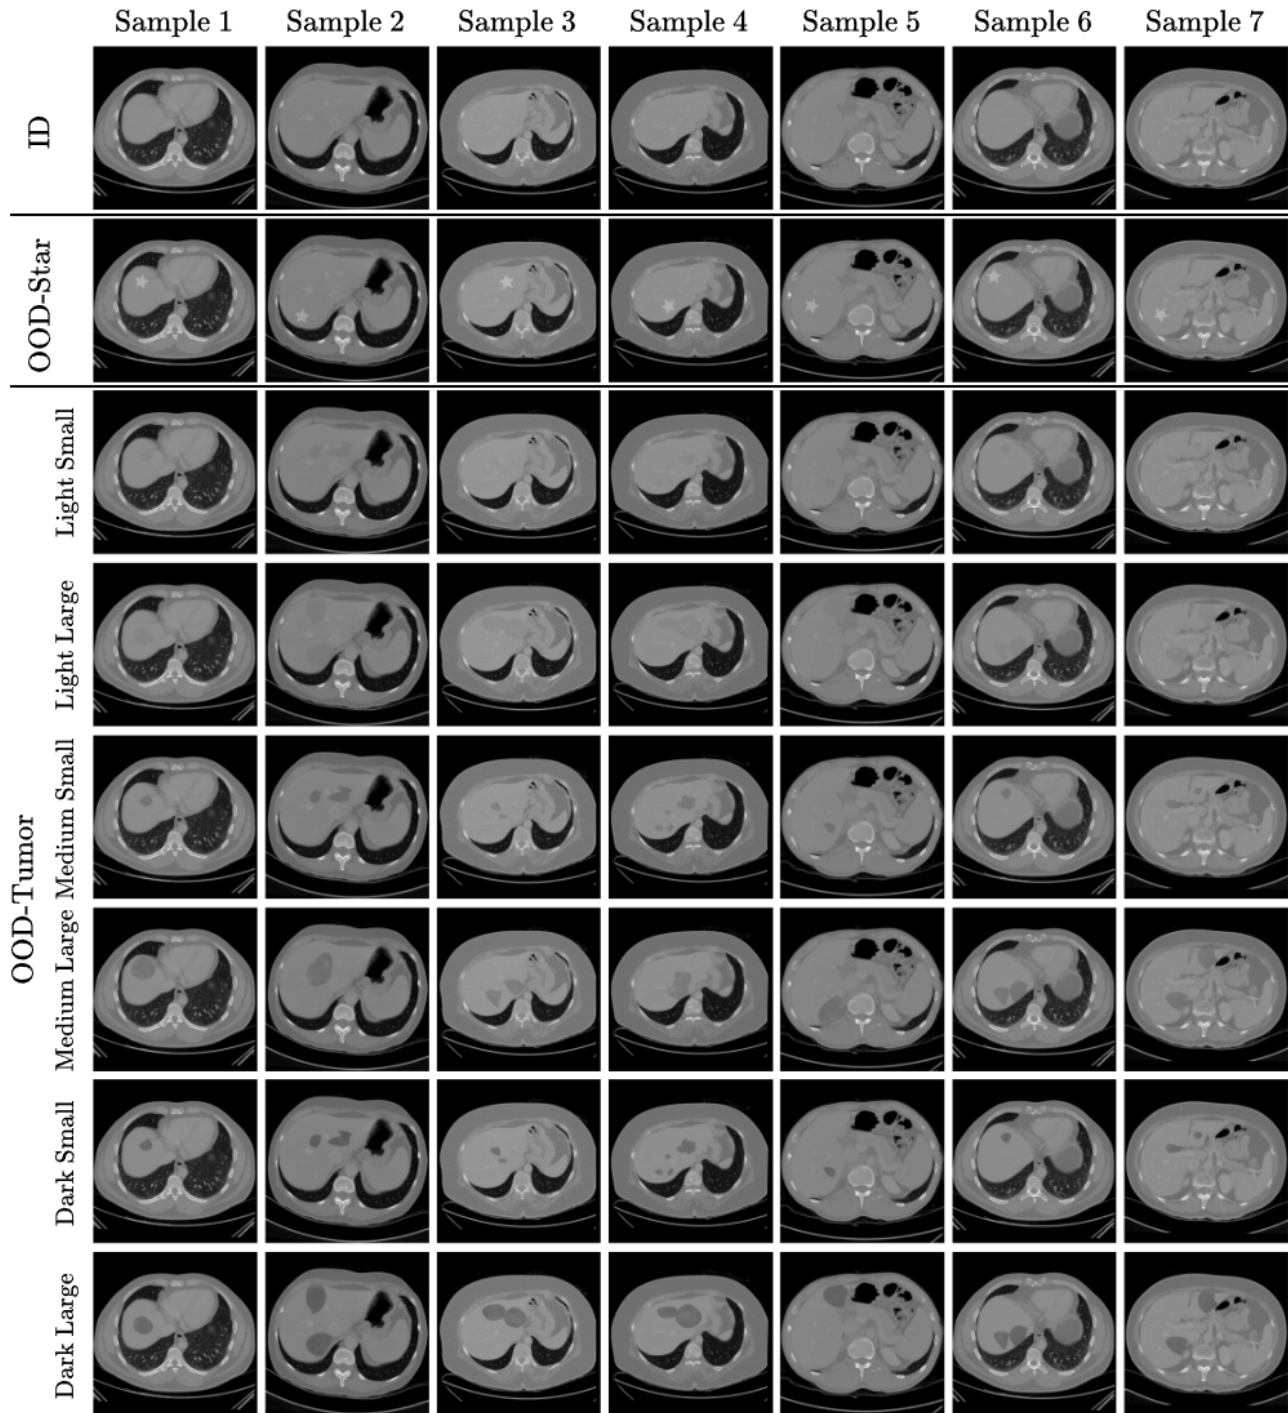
Sample images included in the ID and different OOD sets. Each row represents a distinct dataset, and each column shows 7 different samples from that dataset. From the top, we have (1) the ID set consisted of healthy CT scans from the CHAOS [18] evaluation dataset, (2) the OOD set with a star shaped artifact, used for hyperparameter tuning, and (3) 6 OOD sets containing synthetic liver tumors of different darkness and shape, generated following [15].
